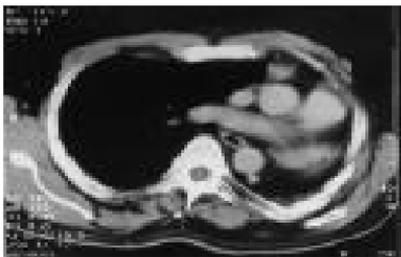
Computed tomogram of thorax showing lack of division of bronchus, right lung herniation, absence of left lung and left pulmonary artery.
